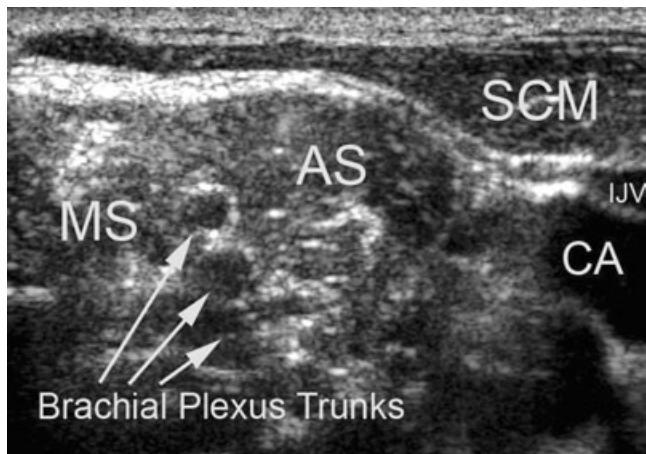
Ultrasound view of the brachial plexus trunks at the C6 level. Note the round appearing nerves between the anterior scalene (AS) and middle scalene (MS) muscles that have a hyperechoic quality surrounded by a hyperechoic perineurium. SCM, sternocleidomastoid muscle; CA, carotid artery; IJV, internal jugular vein.
